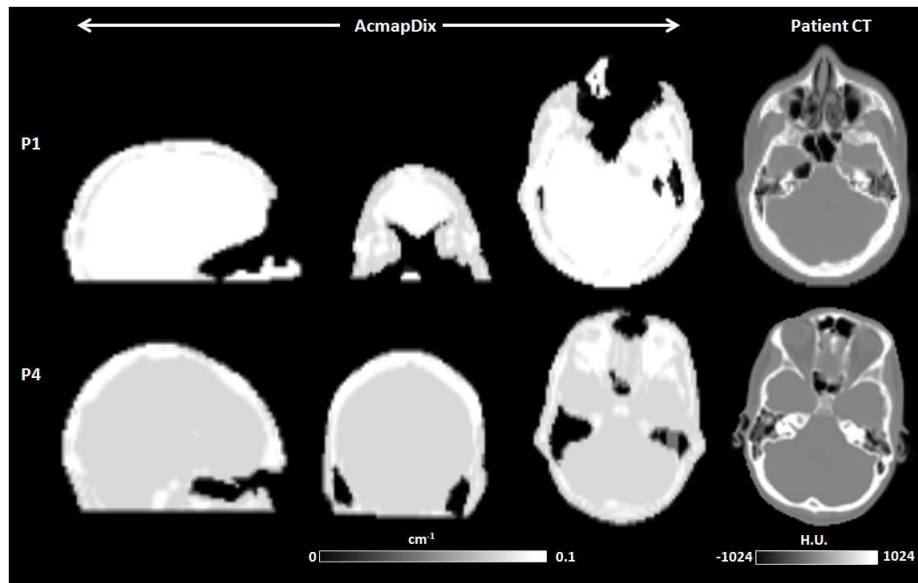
Anomalies in AC map generation for two patients shown in sagittal, coronal and axial orientations alongside patient CT. In patient P1, a dental implant caused severe local signal degradation that propagated onto the corresponding AC map. ACmapDix in patient P4 had inverted water/fat LAC values (water:  $0.1000 \text{ cm}^{-1}$ , fat:  $0.0854 \text{ cm}^{-1}$ ).
